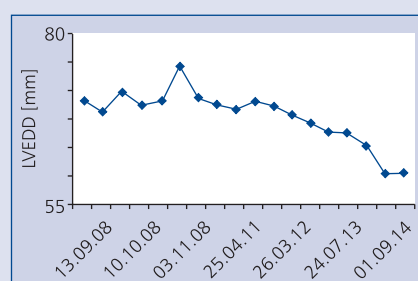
Echocardiographic presentation of left ventricular end-diastolic diameter (LVEDD) during and after mechanical device
